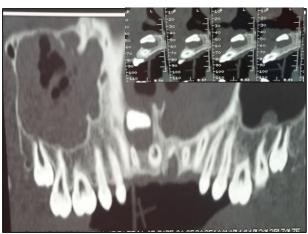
CT scan: high position of the upper central right incisor with a dentigerous cyst
